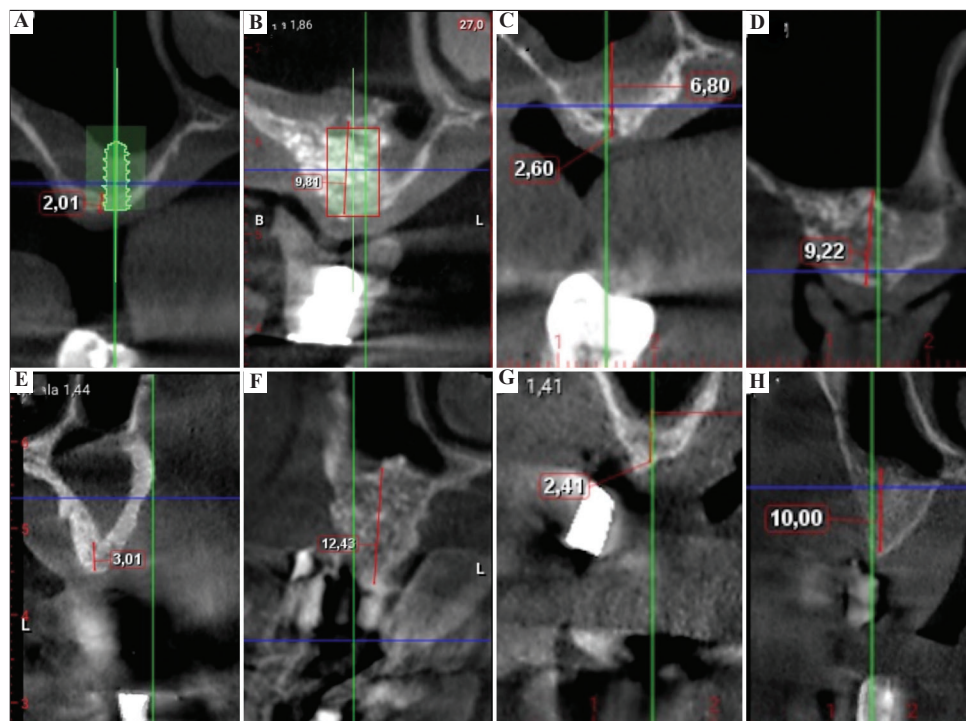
Comparison between test sides and control sides at a radiological level (cone-beam computed tomography [CBCT]). For patient no. 2: repaired Schneiderian membrane (SM) side at baseline (A) and 6 months after sinus lift surgery (B); unrepaired SM at baseline (C) and at 6 months (D). For patient no. 3: repaired SM side at baseline (E) and at 6 months (F); unrepaired SM at baseline (G) and at 6 months (H). In unrepaired SM, there is an apparent increased compaction and maturation of the bone graft.
